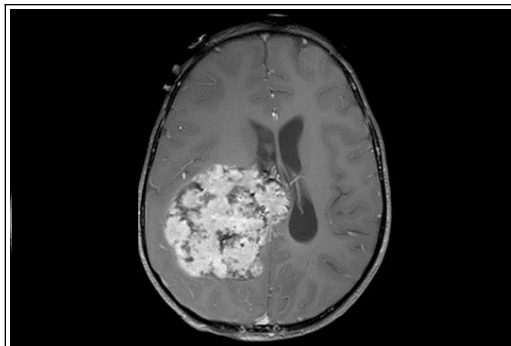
MRI brain, T1 post-contrast
